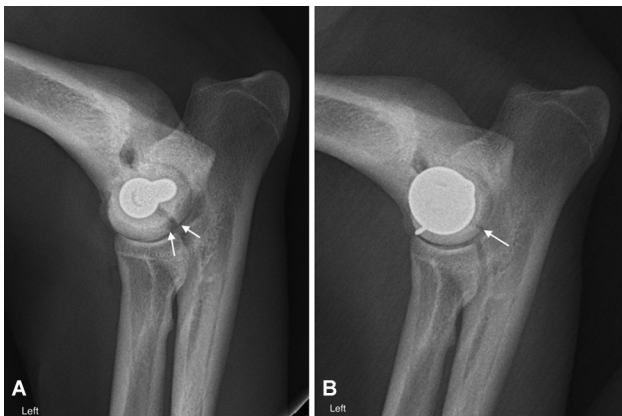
Mediolateral postoperative radiographs of case 1. (A) is the immediate postoperative radiograph with a lateral epicondylar fracture (arrows). (B) is the postoperative radiograph following revision surgery and placement of a flat washer and transcondylar Kirschner wire.
